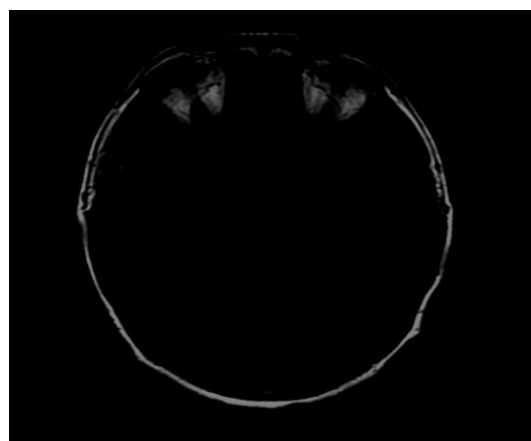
Hyperintensity on FLAIR images involving Superior Sagittal, Right Transverse and Right Sigmoid Sinus.
